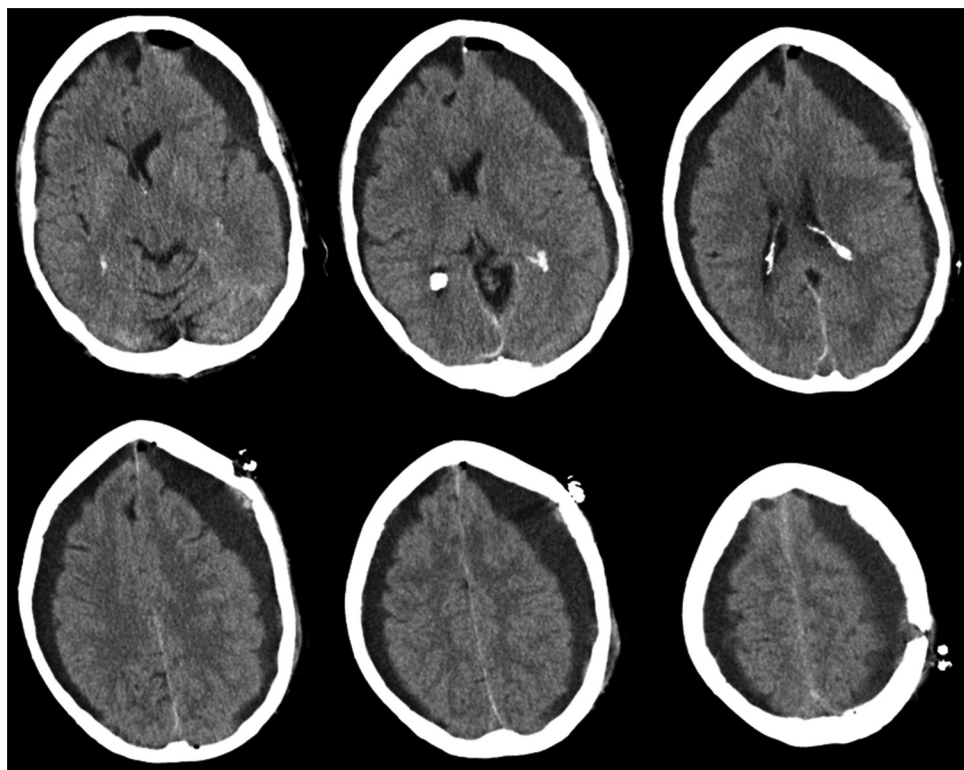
CT head, day 5 postoperative. Evident re-accumulation of the previously drained left sided subdural collection with frontal and parietal burr-holes causing mass effect. The right side collection is bigger causing mass effect and effacement of cerebral surface as well
